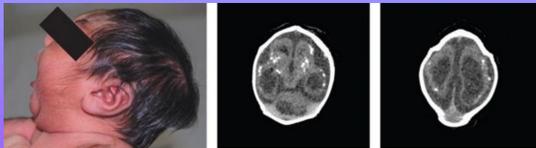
Patient diagnosed with Zika-related microcephaly, noted on CT scan.²
